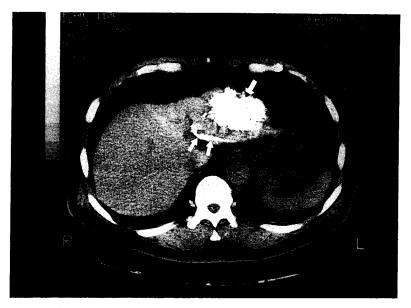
Lipiodol was detected clearly by Lipiodol CT in the main tumor (\uparrow) and throughout the tumor thrombus $(\uparrow\uparrow\uparrow)$.
